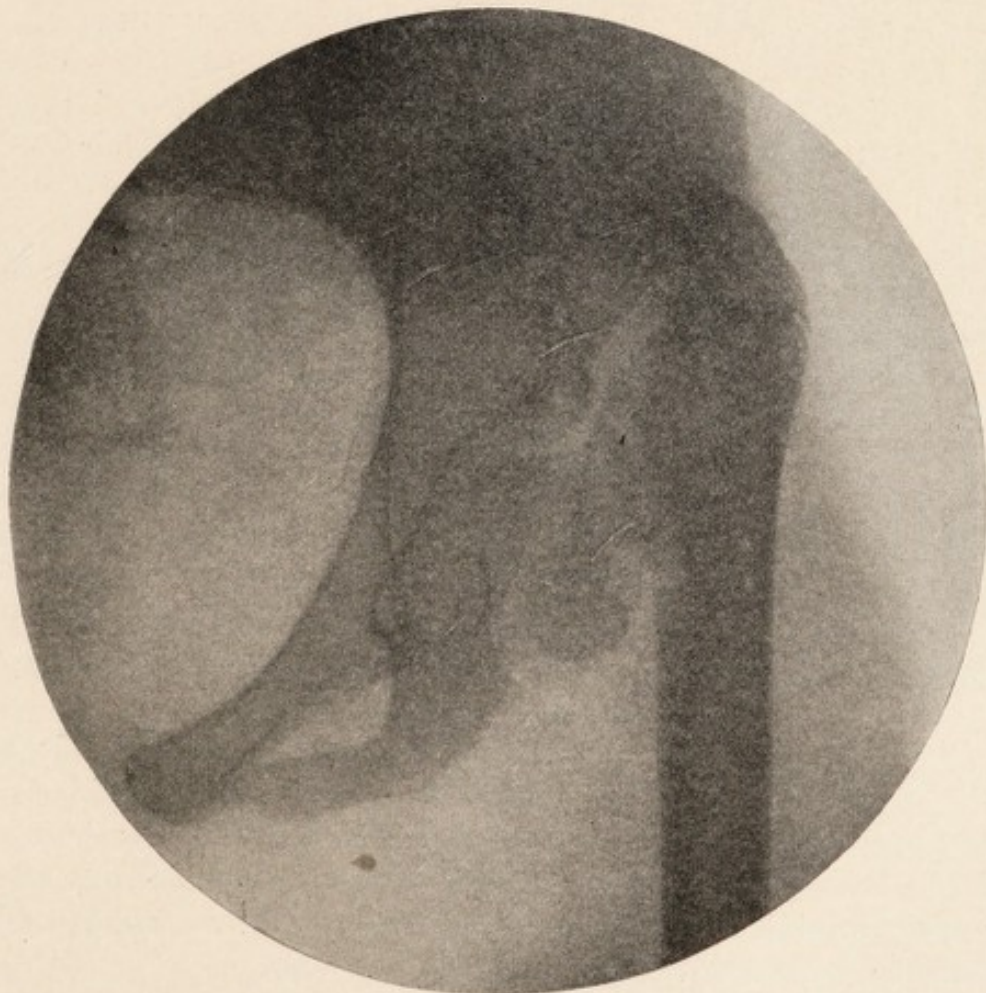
X-ray of same, right side. (*Robert Jones.*)
